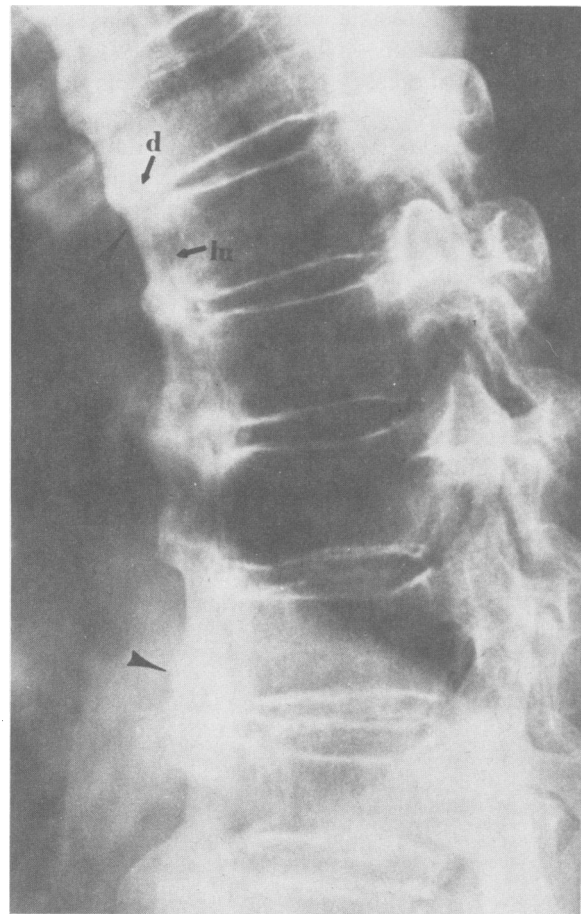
Radiographic film showing hyperostosis of the thoracic spine. Note the anterior linear bone formation (arrowhead) with subjacent radiolucency (lu) and radiolucent disk extensions (d). The height of the disk spaces is relatively preserved.
